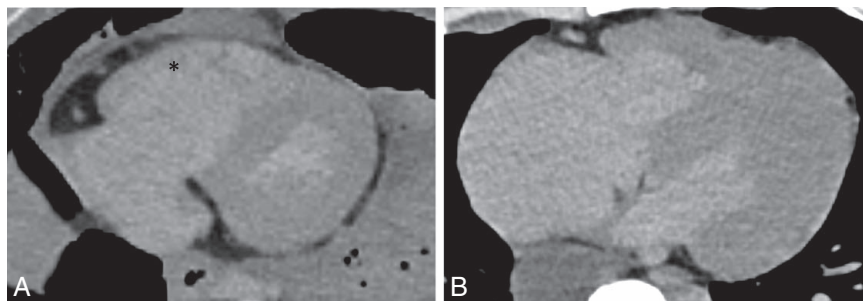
A transverse section of the thoracic cavity on postmortem computed tomography scan showing a distended right atrium and ventricle. The uniform right ventricular wall is hyperdense with whip of hypodense strands (*, A), compared with normal (B).
